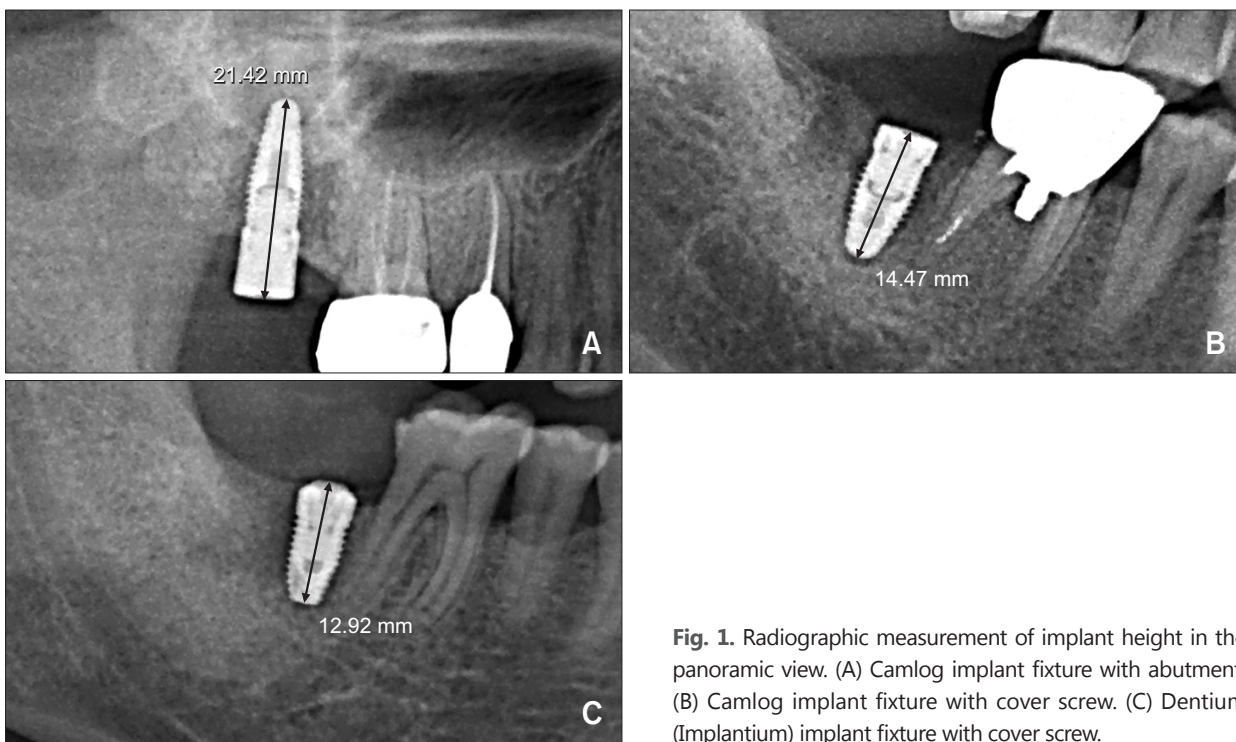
Radiographic measurement of implant height in the panoramic view. (A) Camlog implant fixture with abutment. (B) Camlog implant fixture with cover screw. (C) Dentium (Implantium) implant fixture with cover screw.
